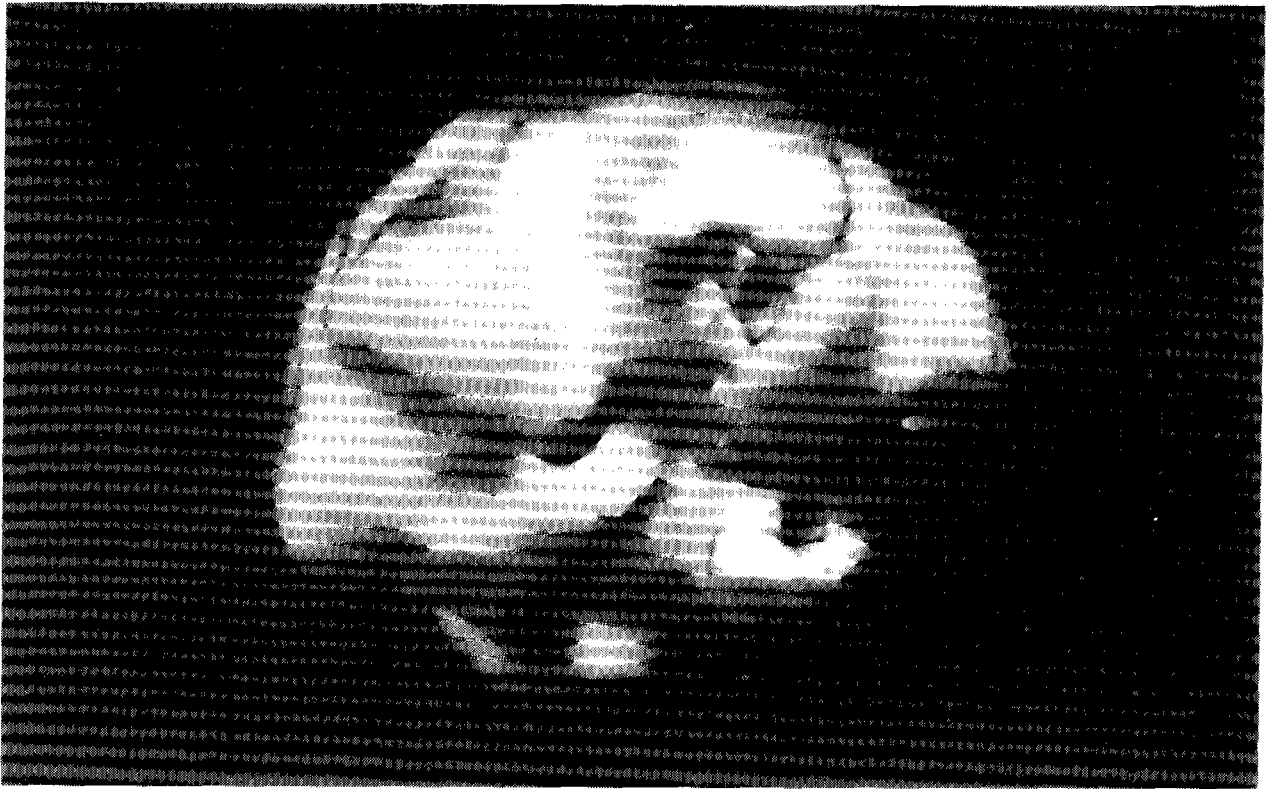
A three dimensional rCBF SPECT study in a patient with major depressive disorder (patient was medication-free). The study demonstrates right inferior frontal hypoperfusion and circumferential (medial worse than lateral) right temporal lobe hypoperfusion.
